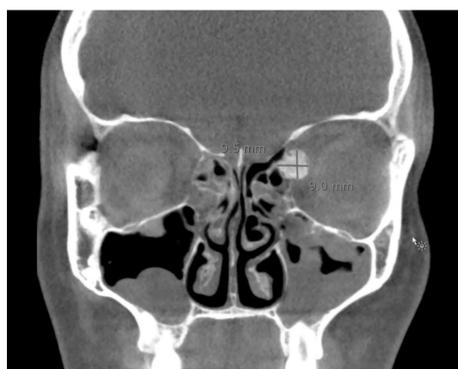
CT Sinus demonstrating oval shaped, calcified lesion, measuring 12 x 9.5 x 9.0mm, arising from left orbital surface of the lamina papyracea.
